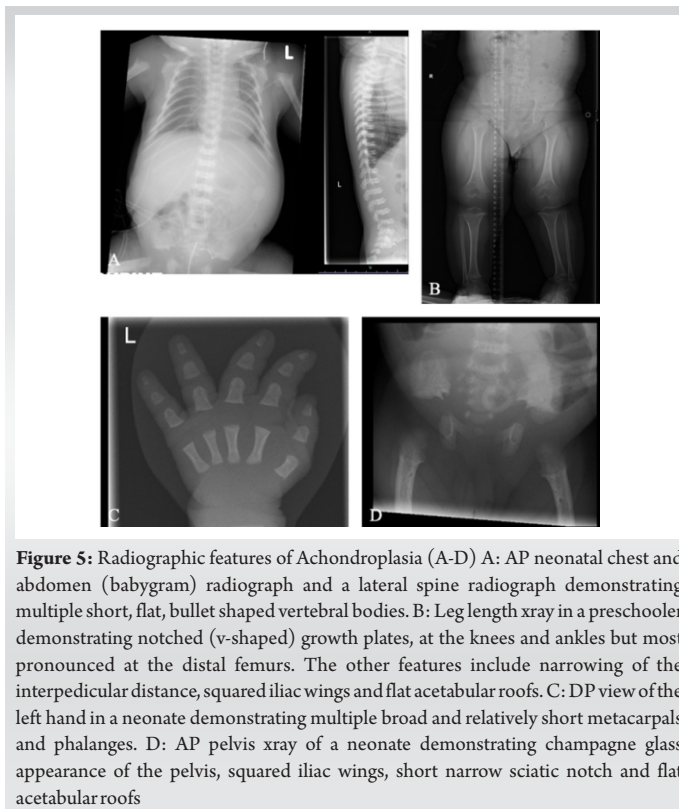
Radiographic features of Achondroplasia (A-D) A: AP neonatal chest and abdomen (babygram) radiograph and a lateral spine radiograph demonstrating multiple short, flat, bullet shaped vertebral bodies. B: Leg length xray in a preschooler demonstrating notched (v-shaped) growth plates, at the knees and ankles but most pronounced at the distal femurs. The other features include narrowing of the interpedicular distance, squared iliac wings and flat acetabular roofs. C: DP view of the left hand in a neonate demonstrating multiple broad and relatively short metacarpals and phalanges. D: AP pelvis xray of a neonate demonstrating champagne glass appearance of the pelvis, squared iliac wings, short narrow sciatic notch and flat acetabular roofs
